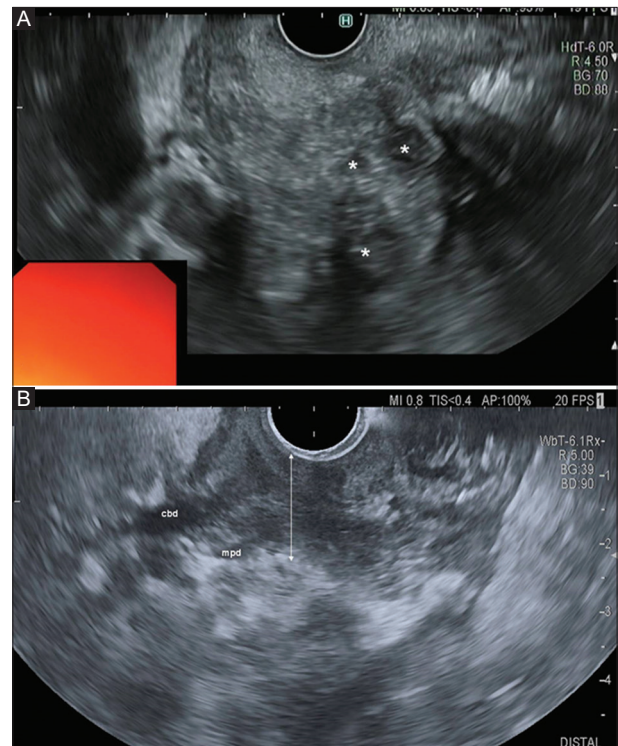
Endoscopic ultrasound images of a paraduodenal pancreatitis. (A) Duodenal wall thickening visualized with the linear echoendoscope, with multiple cysts within the duodenal wall (*). (B) Duodenal wall thickening (double arrow) visualized in the *pars descendens duodeni* with the radial echoendoscope. *Cbd*, common bile duct; *mpd*, main pancreatic duct
